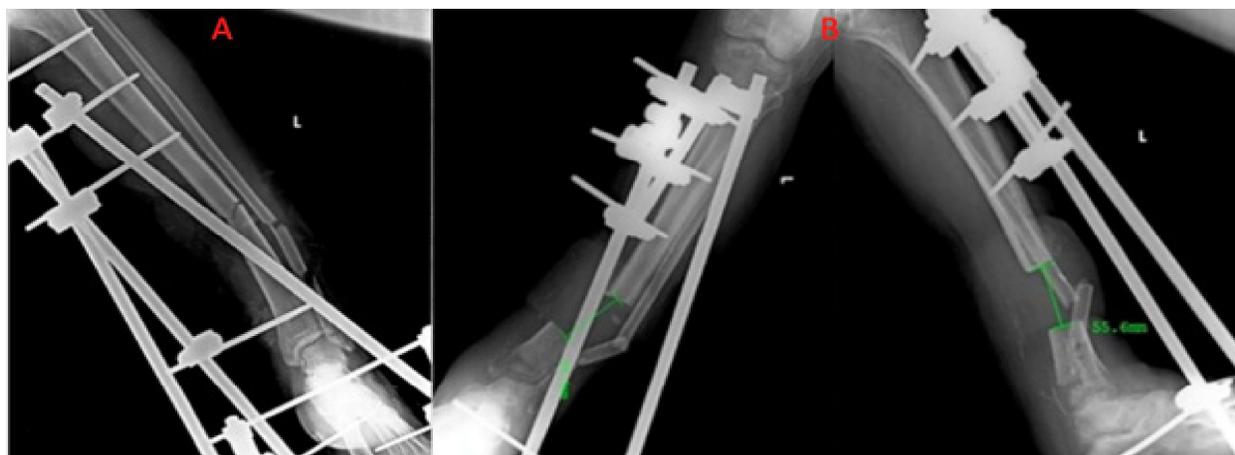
Radiograph A depicts the immediate post-operative fixation using A - External fixator whereas radiograph B depicts post removal of the infected bone segment with a bone loss of 55 millimeters three months following index surgery
